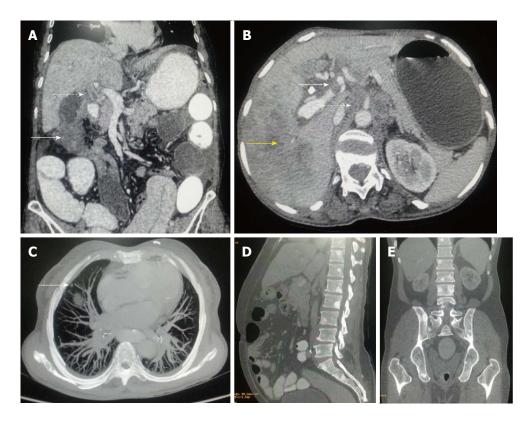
Gallbladder carcinoma: regional and distant metastasis. A: Axial contrast-enhanced computed tomography abdominal section shows heterogenous mass lesion involving fundus of gall bladder fossa (arrow) with associated circumferential enhancing wall thickening of CBD (dashed arrow) indicating cholangitis or intraductal spread of malignancy; B: Axial CECT abdominal section shows hypodense filling defect in left branch of portal vein indicating thrombus formation (arrow). Hepatic infiltration is seen in segment VII (yellow arrow) with retroperitoneal lymph nodal metastasis (dashed arrow); C: MIP axial CT imaging shows soft tissue nodule in anterior segment of right lung indicating pulmonary metastasis (arrow); D and E: Sagittal and coronal CECT abdominal sections (bone window) show multiple osteoblastic skeletal metastatic lesions. CBD: Corticobasal degeneration; CECT: Contrast-enhanced computed tomography.
